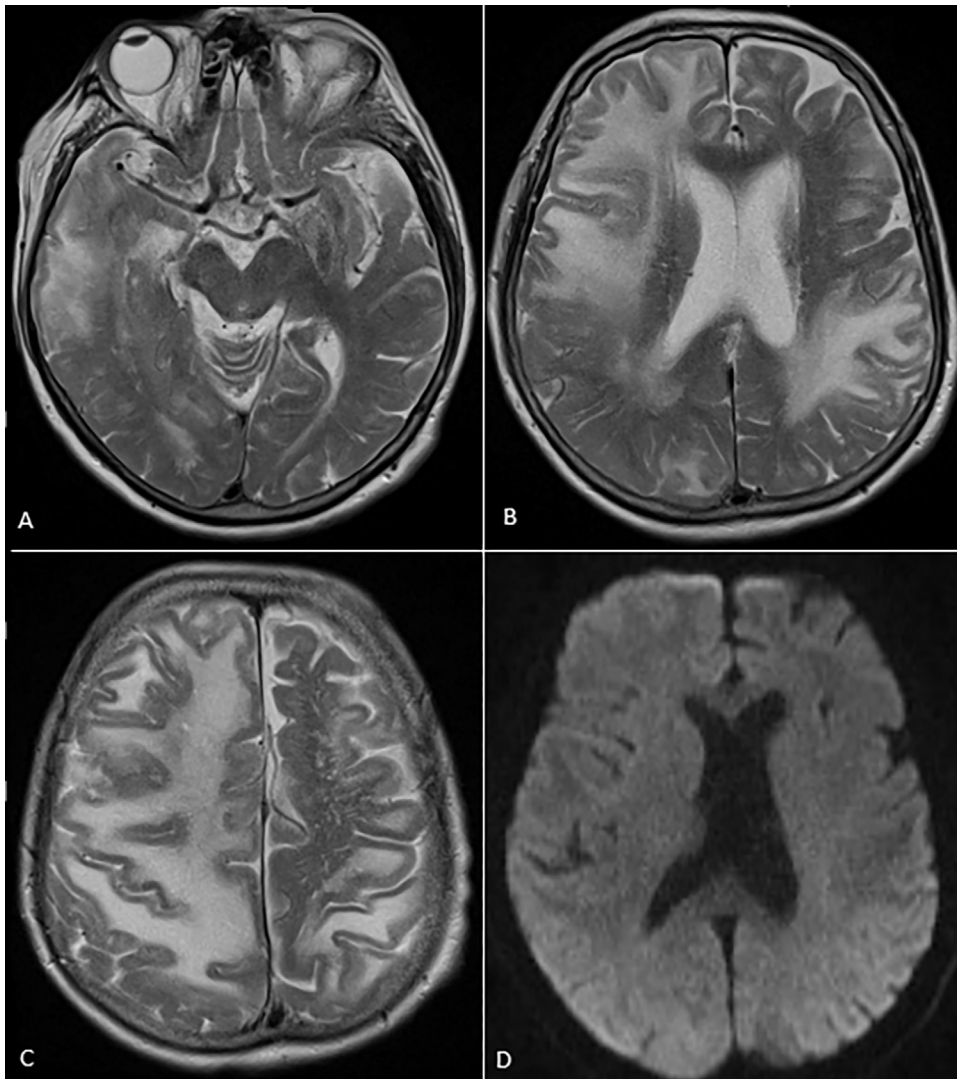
First hospitalization – diffused hyperintensive changes on T2-weighted images localized subcortically in the white matter of both cerebral hemispheres (A-C), vasogenic edema in DWI option (D).
